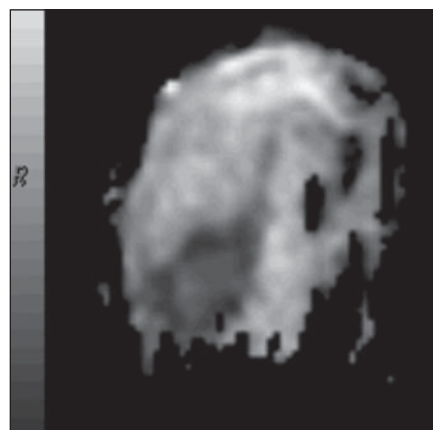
40-year-old woman with invasive ductal carcinoma in right breast. A–F, Axial maximum intensity projection of contrast-enhanced T1-weighted 3D spoiled gradient-echo image, first phase, submitted to subtraction technique (A) and axial black-and-white apparent diffusion coefficient (ADC) maps obtained from five b values (0, 250, 500, 750, and 1,000 s/mm²) (B), 0 and 250 s/mm² (C), 0 and 500 s/mm² (D), 0 and 750 s/mm² (E), 0 and 1,000 s/mm² (F) show enhancing irregular mass, with increased signal loss on ADC maps, which means restricted diffusion.
